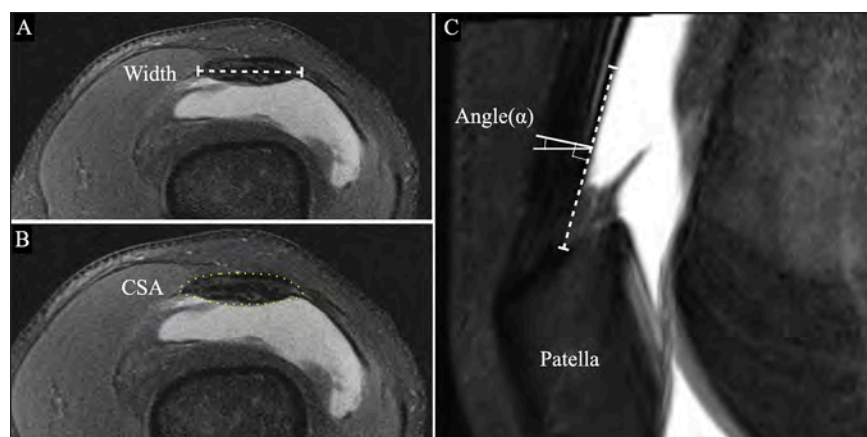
Measurement for the width, cross-sectional area (CSA), and thickness of the tendon on MRI. A. The width was measured on axial plane. B. CSA was measured on axial plane. C. The thickness was measured on sagittal plane.
